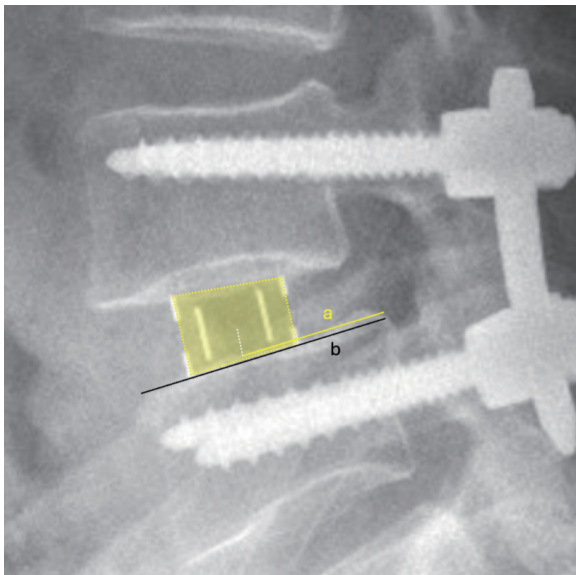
Measurement of the cage position in the lateral x-ray image. The cage position is determined by the formula $a/b \times 100$ (%). (a) The distance from the posterior border of the superior endplate of the lower vertebral body to the center of the interbody cage. (b) The length of the superior endplate of lower vertebral body.
